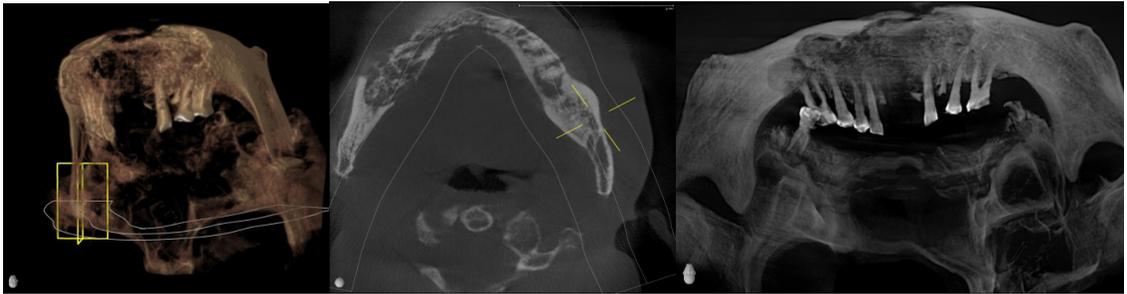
Cone-beam CT image showing extensive necrotic lesion of the mandible with discontinuity of the mandibular basal border
